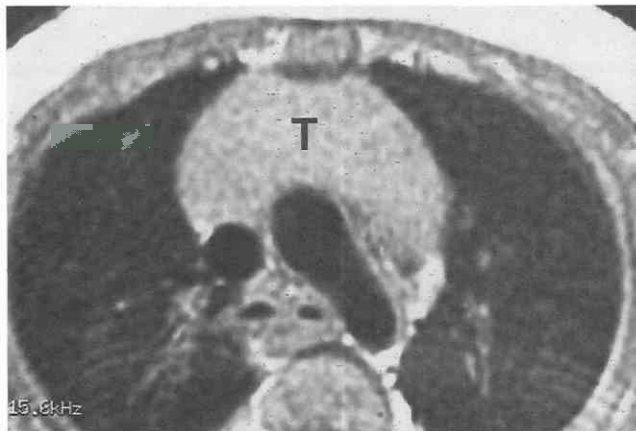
Normal thymus in a 6-month-old girl. Axial, T1-weighted MR image shows thymus (T) to be homogeneous in signal and to have convex margins.
